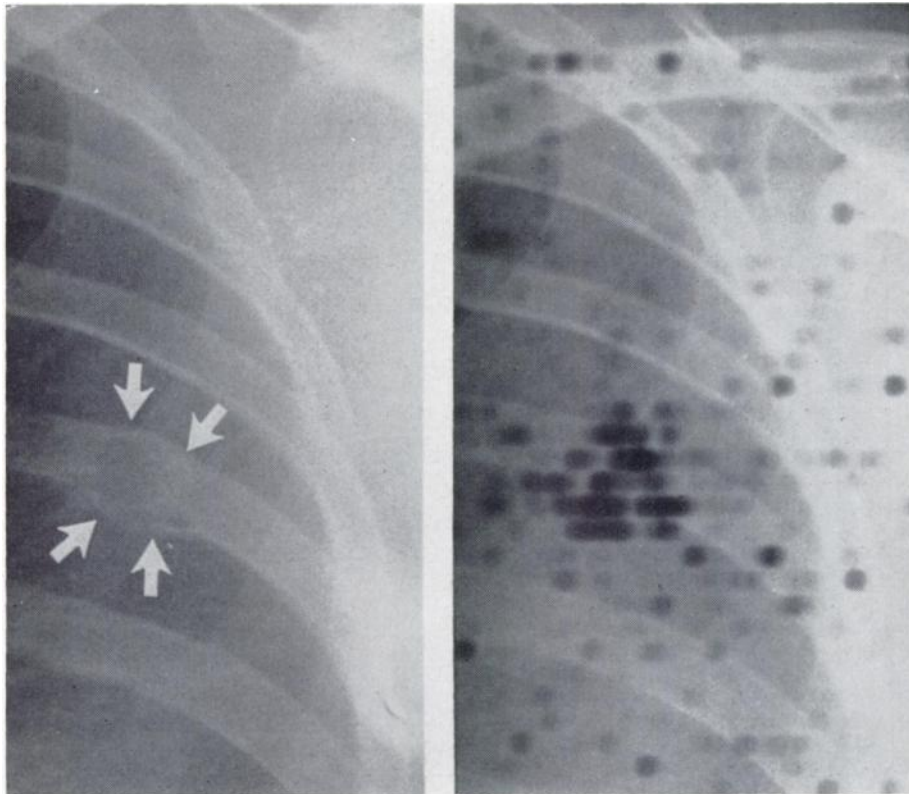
46 year old female with widespread metastatic breast cancer to bone. (left): Pathologic fracture of left 6th rib with callus formation. (Right): Sr-⁸⁵ scan superimposed on roentgenogram. Note close correspondence of scan volume and that of fracture site.
